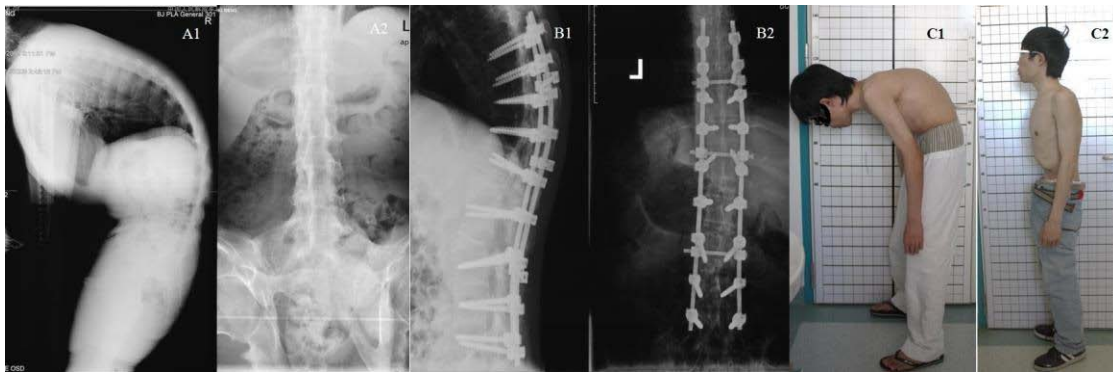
A 23-year-old male with AS kyphosis deformity secondary to AS underwent a 2-level PSO correction. (A1-2) Preoperative standing lateral and anteroposterior radiographs, the patient then underwent L1 and L3 PSO. (B1-2) Postoperative lateral and anteroposterior radiograph
